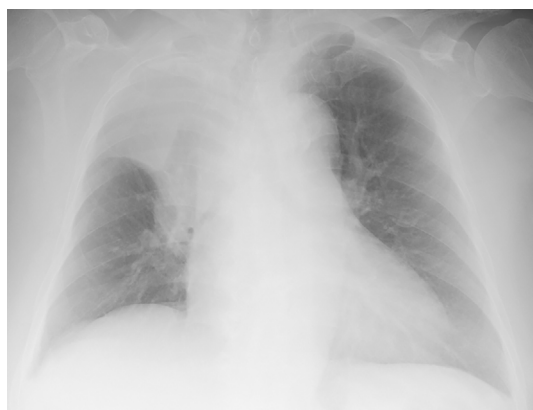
A chest radiograph showing collapse of the upper lobe of the right lung over a reverse S-shaped minor fissure (Golden S sign).
